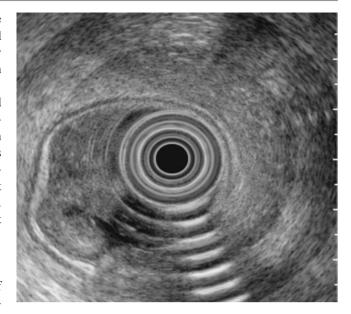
Endorectal ultrasound of T1 tumor. (Courtesy of Lehel Somogyi, MD)
